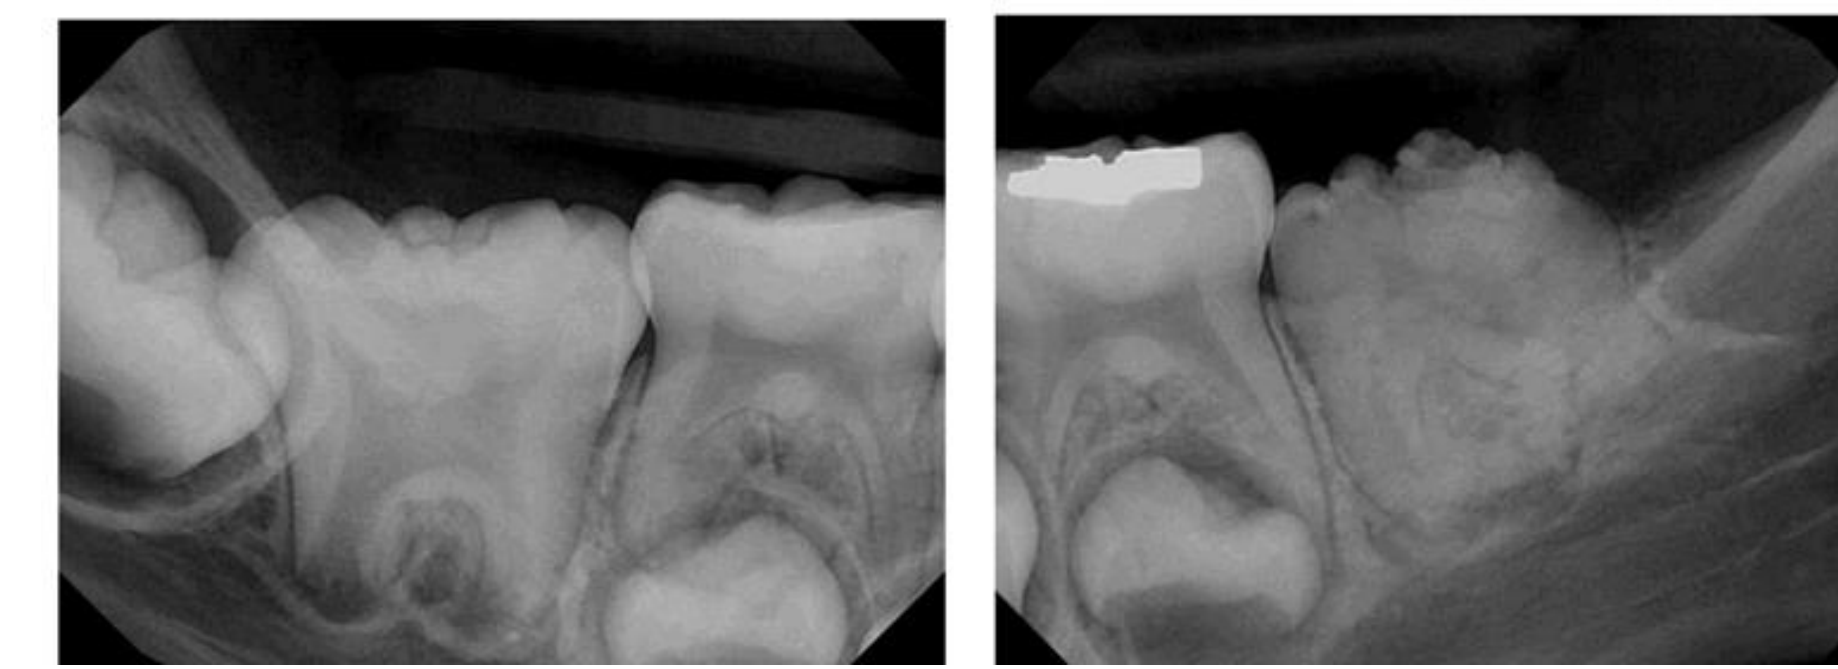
Right and Left periapical radiographs, respectively.
